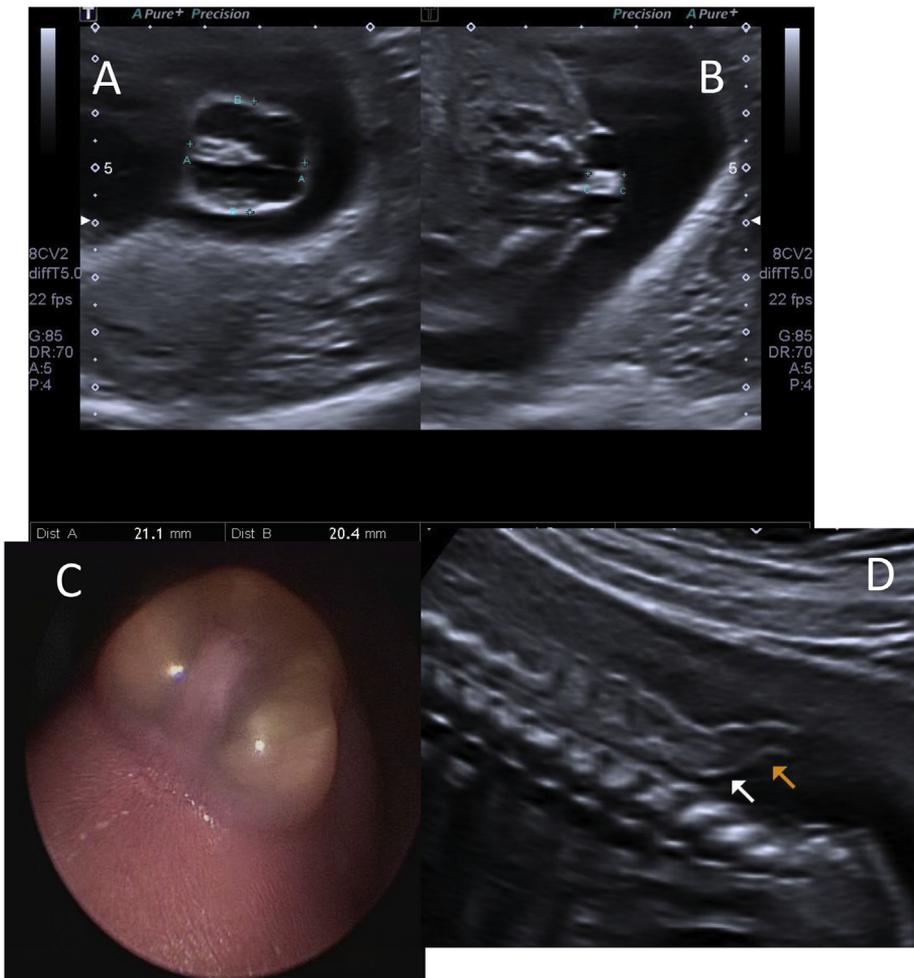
Ultrasound images (A, B, and D) of a meningomyelocele defect at 26 weeks and the corresponding fetoscopic image of the defect (C).
